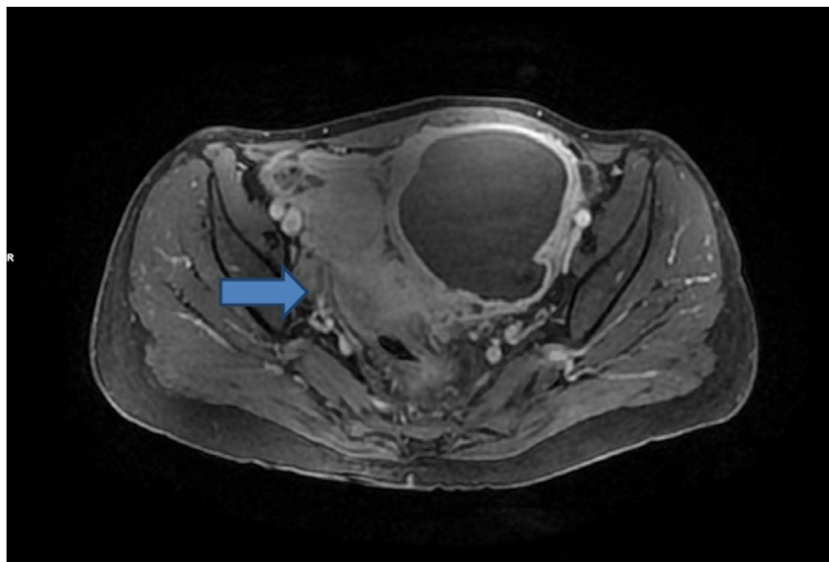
Pelvic MRI showing 10.2 × 8.7 × 8.8 cm left tubo-ovarian abscess presenting an intermediate signal in T2 with a restriction of the diffusion (arrow).
